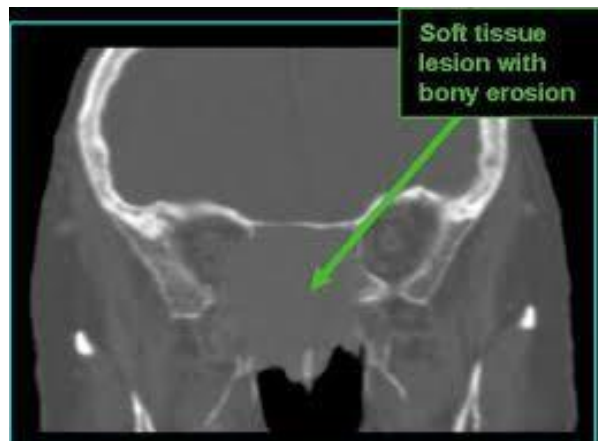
shows coronal bony CT image with lymphoma within nasophrenx (<https://medicine.uiowa.edu>)
